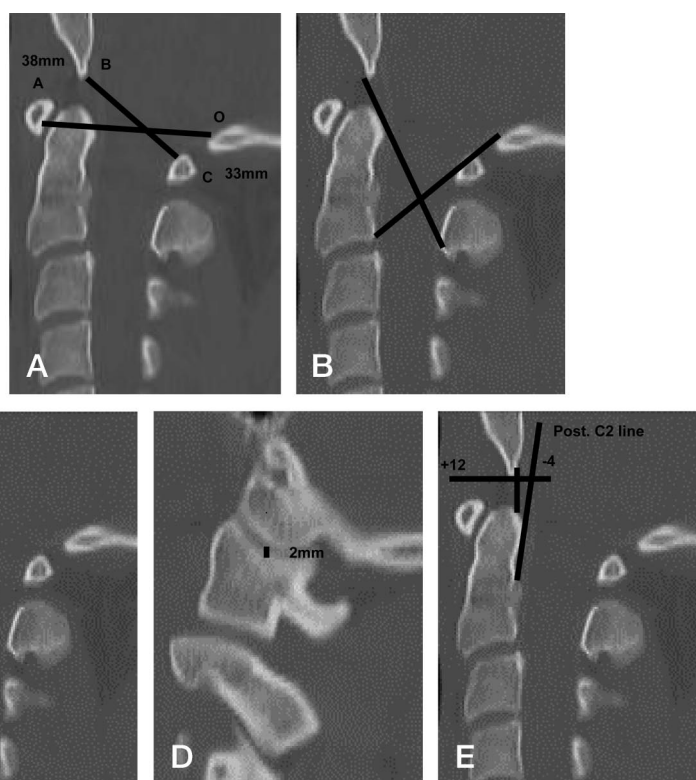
Methods to diagnose AOD shown on CT scans of a patient without injury. A, Power's ratio-line segments BC/OA, 33/38 mm = 0.87. B, X-line method. Posterior-superior aspect of dens and spinolaminar line at C1 are intersected. C, Basion-dens interval, <10 mm. D, Condylar gap, 2 mm with no displacement. E, Harris method. Basion-dens interval of 7 mm with no displacement.
